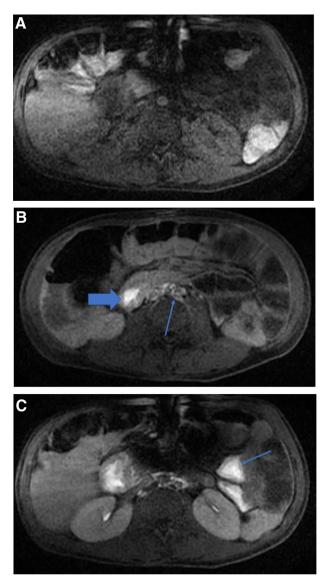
A) Precontrast axial liver acceleration volume acquisition (LAVA) MRI before gadolinium contrast injection. B) Axial LAVA after inguinal intranodal gadolinium injection showing retroperitoneal lymphatics (thin arrow) and early extravasation of contrast into the duodenum (thick arrow). C) Delayed postcontrast axial LAVA demonstrates accumulation of duodenal contrast and flow of contrast into the jejunum (arrow).
